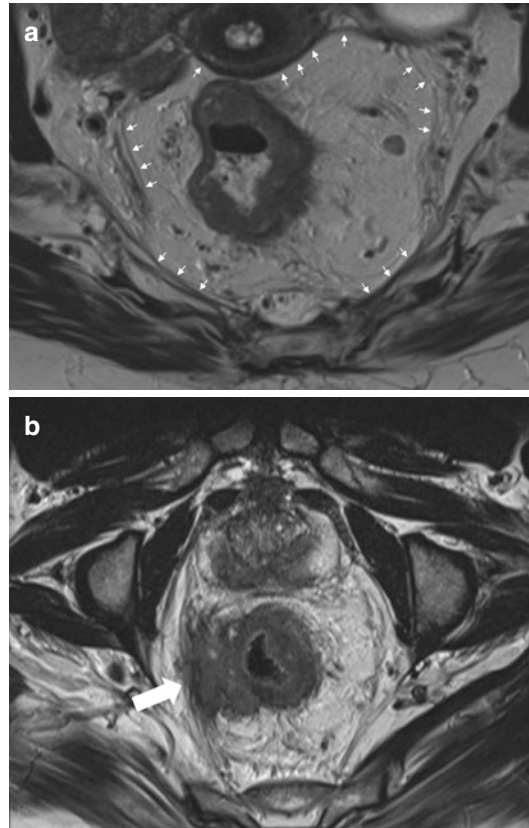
(a) Axial T2-weighted MRI section showing the circumferential mesorectal fascia (*white arrows*) encasing the mesorectum. In this case, the mesorectal fascia has not been invaded by the tumour (not shown). (b) Axial-Oblique T2-weighted image of a mid rectal tumour (*white arrow*) that has perforated through the mesorectal fascia on the right, with surrounding inflammatory changes
